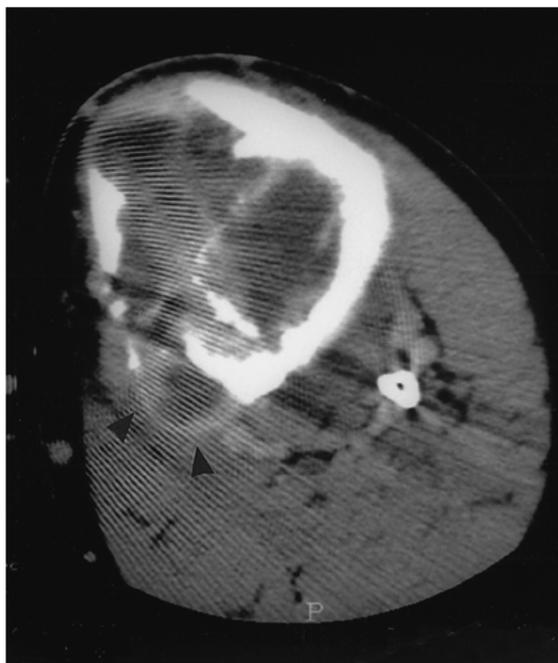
Computed tomography scan showing an osseous lesion, disruption of the tibial cortex, and an extraskeletal tumor mass (arrowheads).
